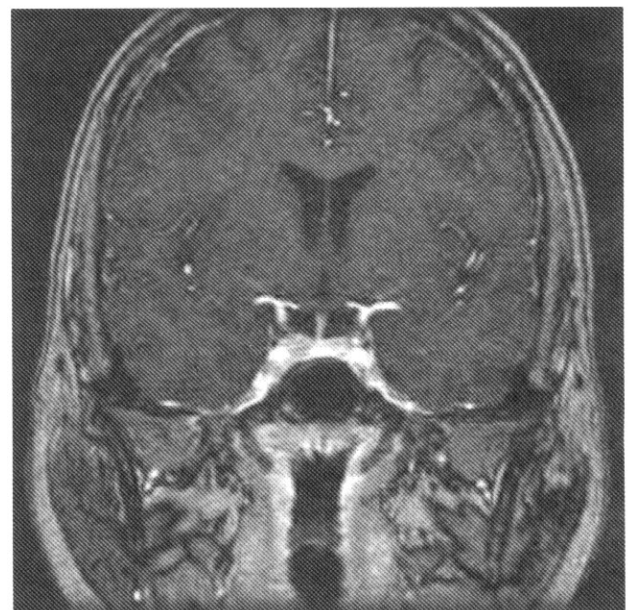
Magnetic resonance imaging shows focal low signal intensity lesion in right inferior portion of pituitary gland.
